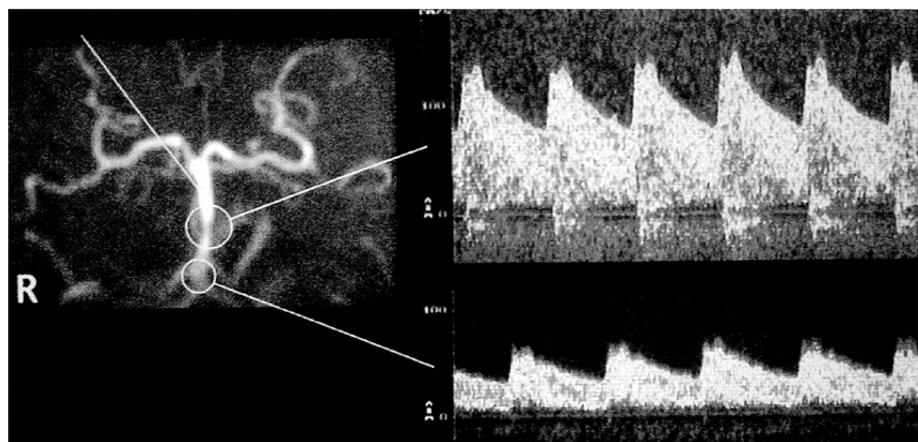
Doppler sonography from arterial lumen. (SmartWire or FloWire)
